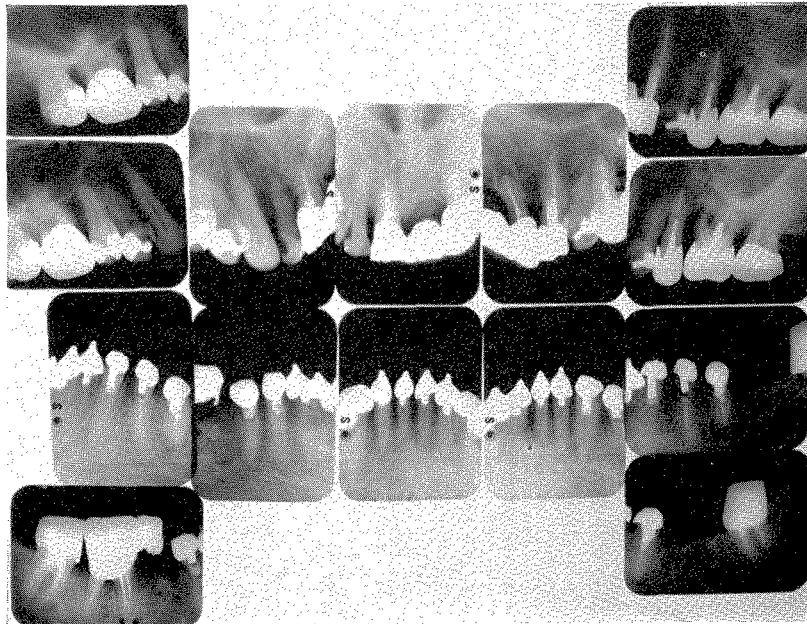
Roentgenograms taken in 1952 showing the condition of the oral structures upon presentation.
